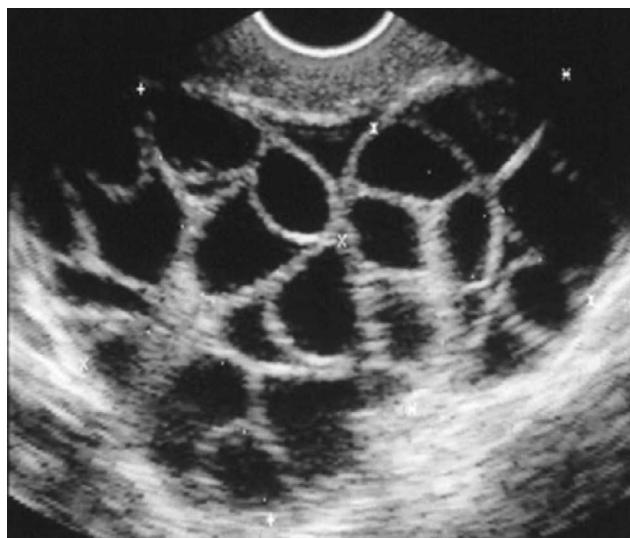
Hyperstimulated ovaries following ovarian stimulation. (Image adapted from Smith, Laura P. “Ultrasound and ovarian hyperstimulation syndrome.” *Ultrasound Imaging in Reproductive Medicine*. Springer, Cham, 2019. 321–333.)
